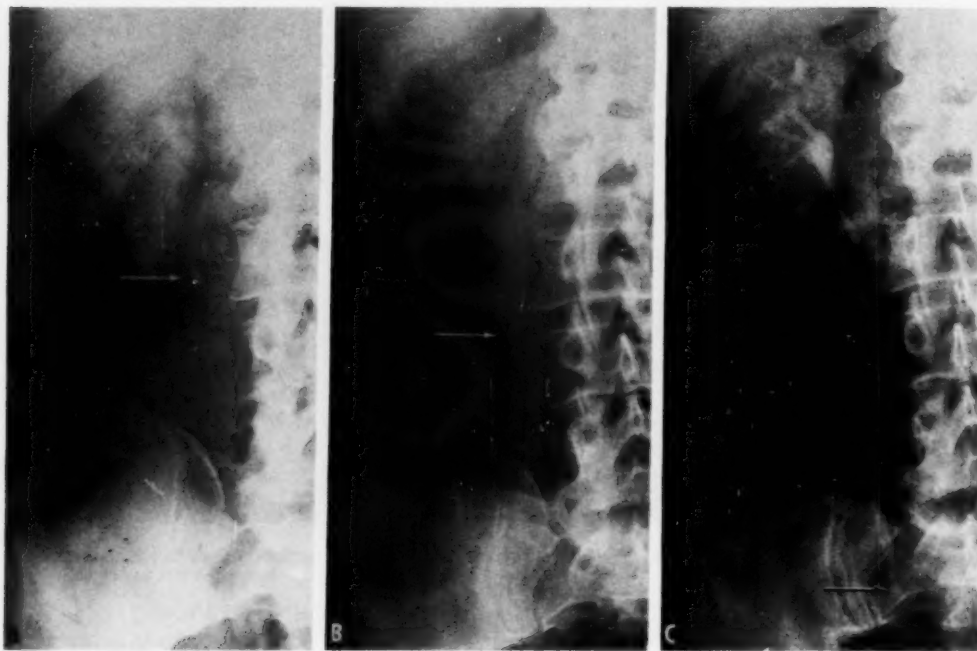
A. Plain film obtained on admission, disclosing abnormal right upper quadrant calcification.
